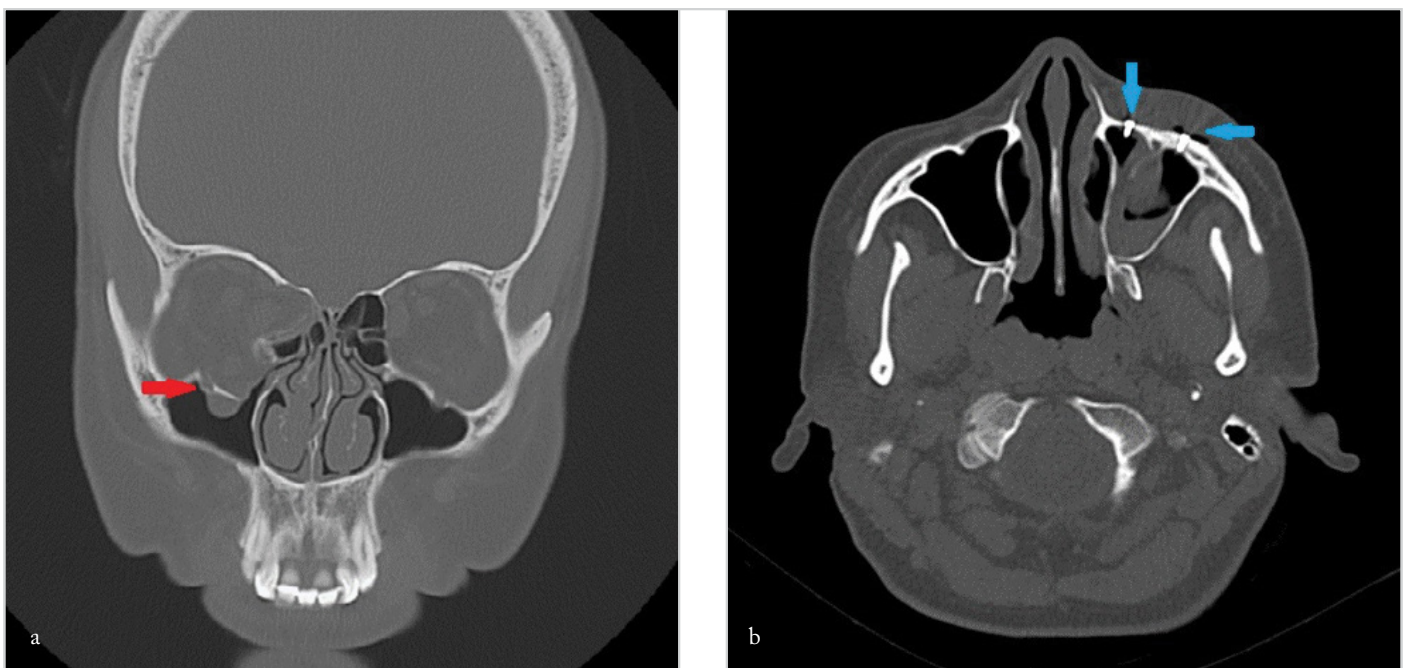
a, b. Coronal CT scan shows blow-out fracture on the right side (red arrow) (a). Postoperative axial CT scan demonstrates internal fixation by miniplates (blue arrows) (b)
